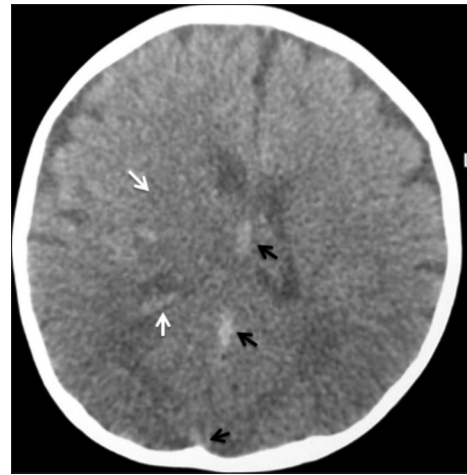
Non-enhanced head computed tomography (CT) showing linear hyperdense cord sign involving the deep venous system (black arrows), hemorrhages and hypodense (white arrows) right thalamus, and basal ganglia
